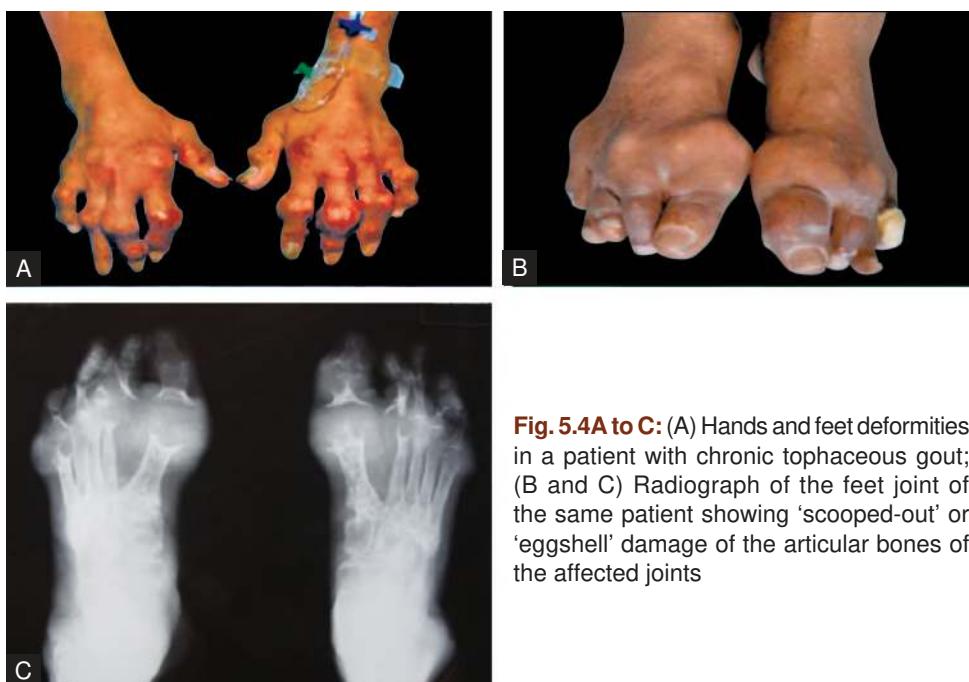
to C: (A) Hands and feet deformities in a patient with chronic tophaceous gout; (B and C) Radiograph of the feet joint of the same patient showing 'scooped-out' or 'eggshell' damage of the articular bones of the affected joints
